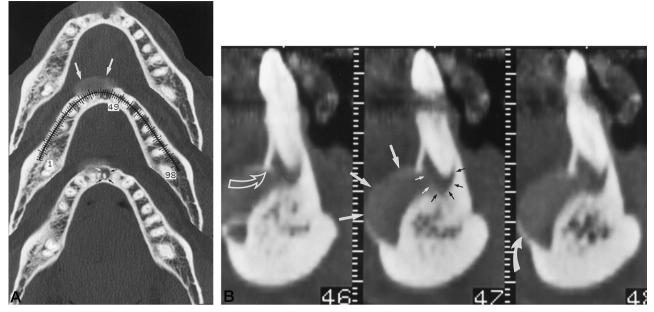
Axial (A) and cross-sectional (B) DentaScan images show a Silastic implant (*large arrows*) that has eroded into a periapical abscess (small arrows) surrounding the left central incisor. In B, the cortical margin is absent in the place in which the implant meets the periapical radiolucency (open curved arrow). Note how heterotopic new bone formation (solid curved arrow) tends to surround the implant.
